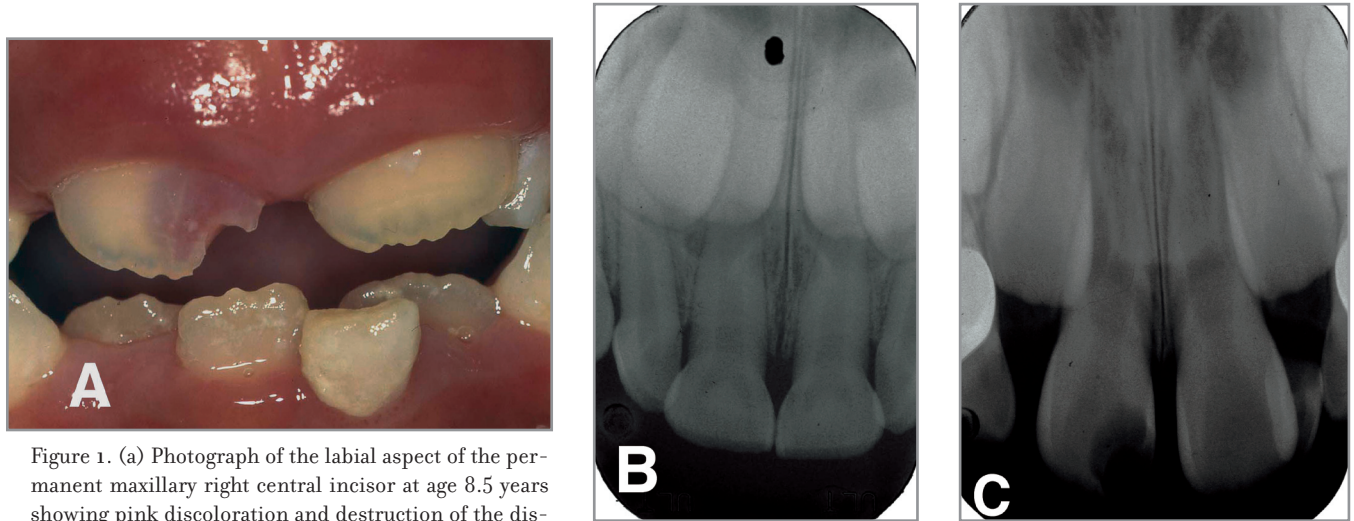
(a) Photograph of the labial aspect of the permanent maxillary right central incisor at age 8.5 years showing pink discoloration and destruction of the distal region of enamel. (b) Periapical radiograph at age 6 years showing normal development of the permanent maxillary right central incisor. (c) Periapical radiograph at age 8.5 years showing a large radiolucency close to the pulp (from Abe M et al¹⁸).
